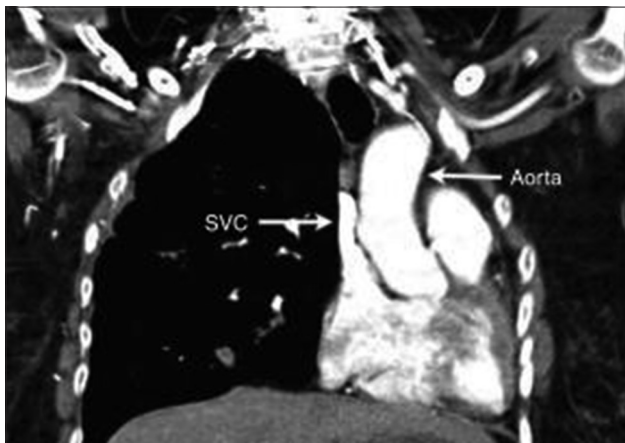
Catheter misplacement to the mediastinum.^[6] The computed tomography image shows the mediastinum grows for the huge hematoma. SVC: Superior vena cava.
